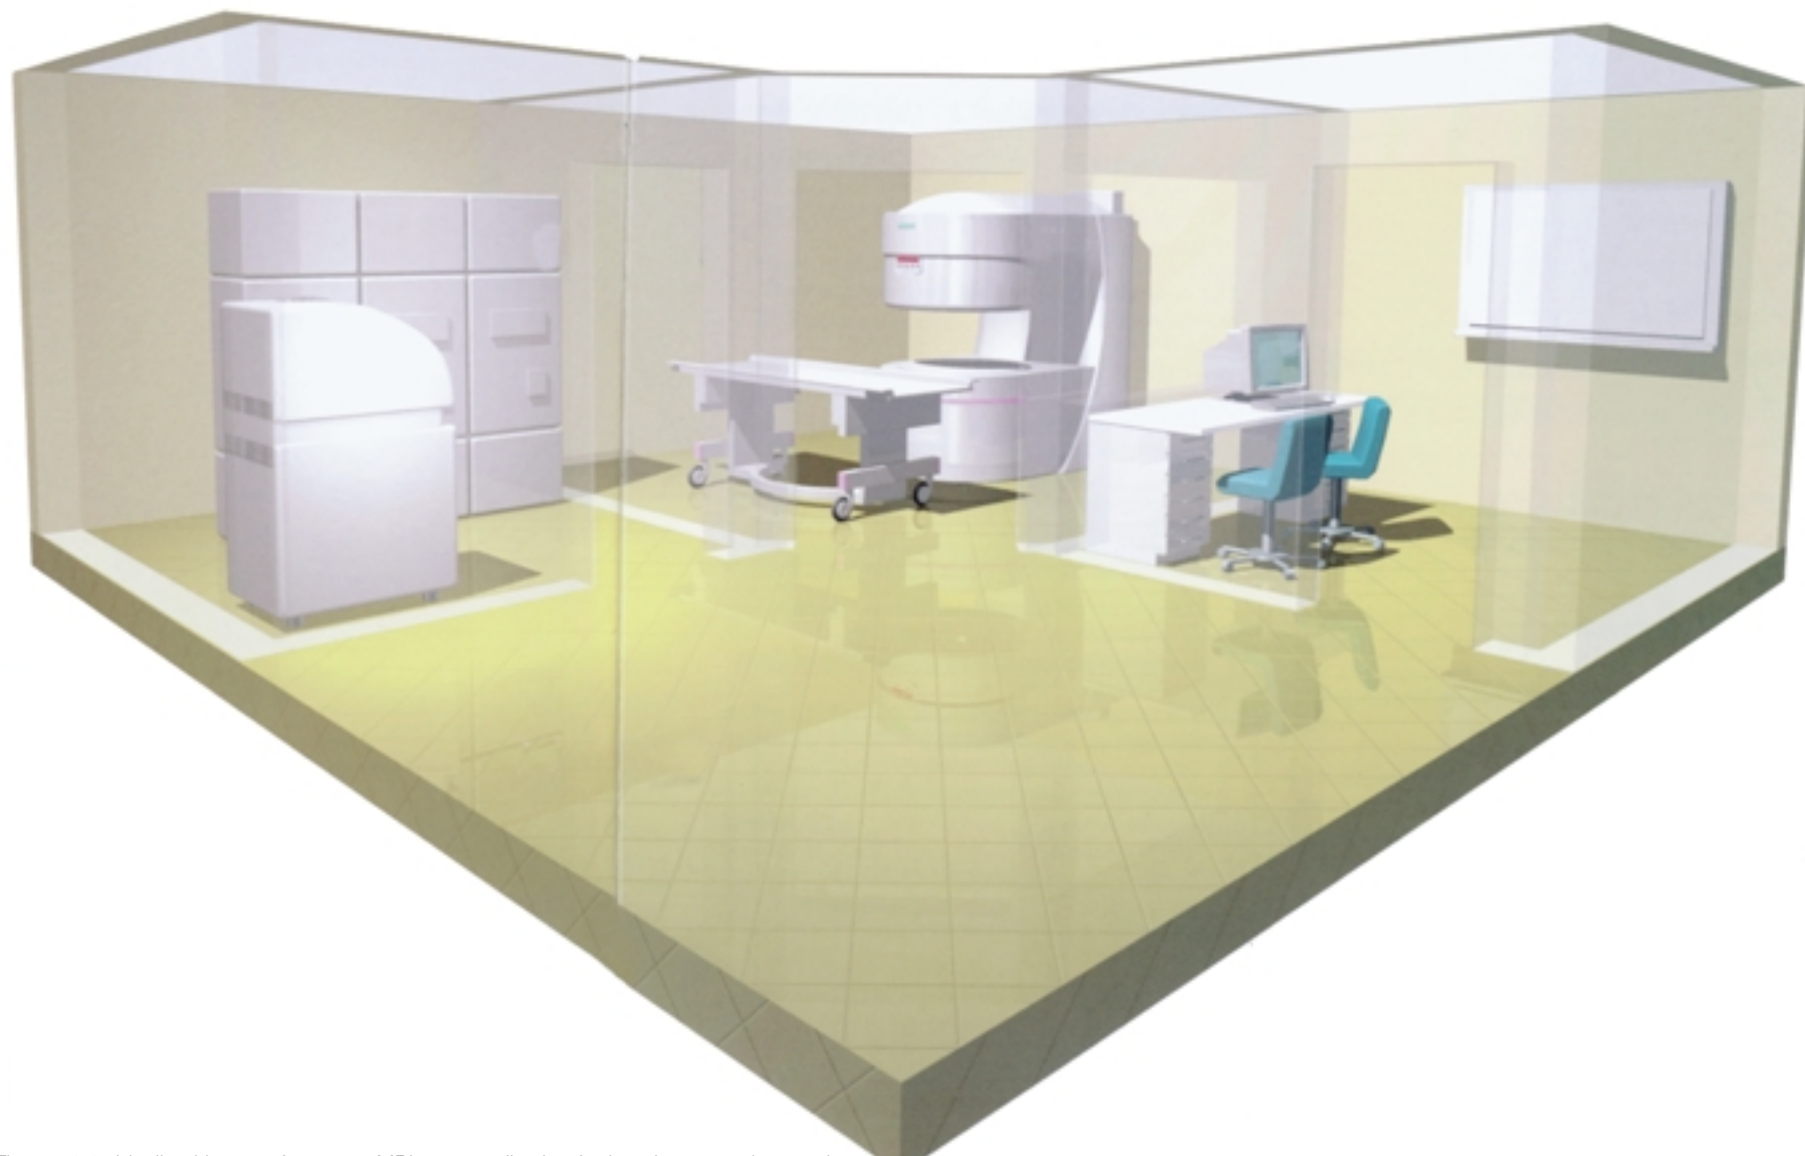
Idealised layout of an open MRI system allowing for imaging procedures only.
